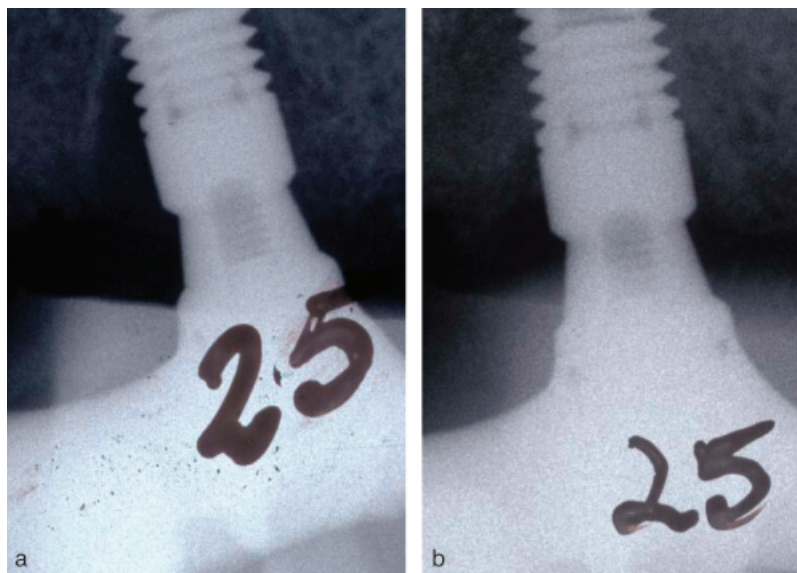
(a) Initial radiograph demonstrating peri-implant bone loss. (b) One-year radiograph demonstrating defect fill.
